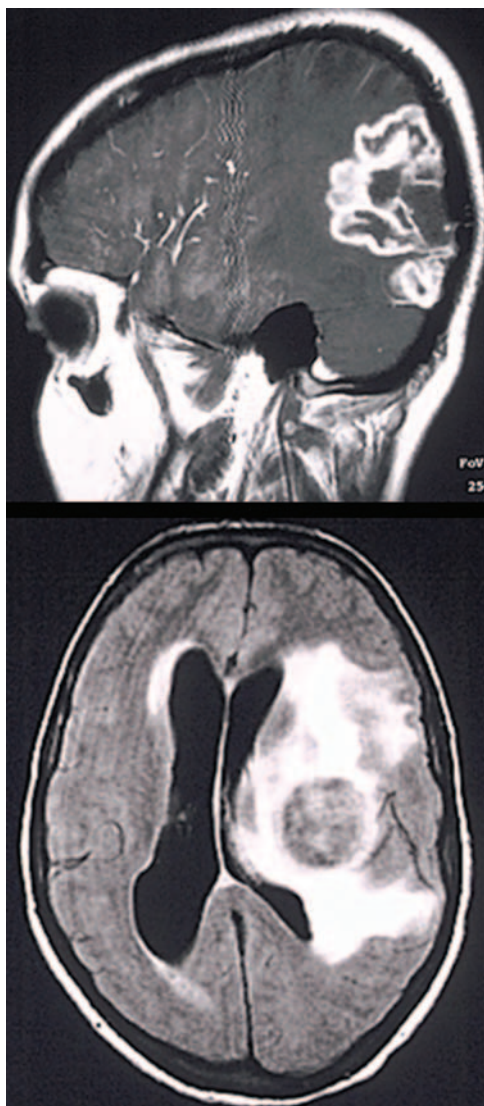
MRI of CNS tuberculoma. Contrast-enhanced scans show CNS tuberculoma.
